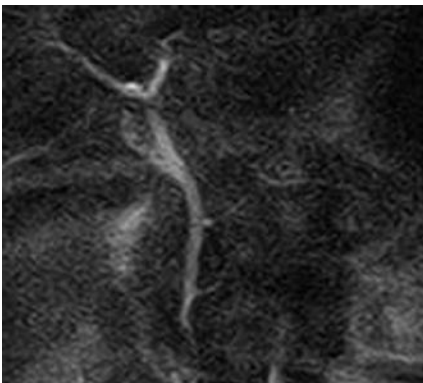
Magnetic resonance image in a 48-year-old woman with abnormal arrangement of the pancreato-biliary ductal system without a choledochal cyst.
